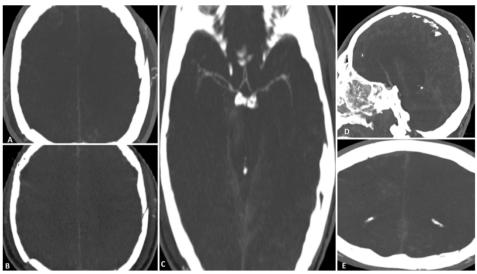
CTA showing BD. Despite subarachnoid and cisternal hemorrhage, arterial (A, B, and C) and venous (B and E) phases reveal the absence of MCAs and ICVs.
